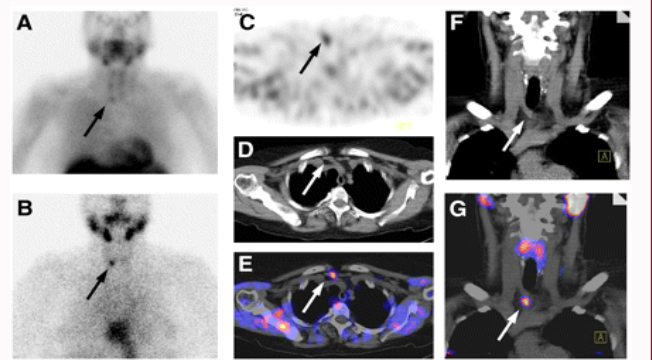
SPECT CT White Arrows (F) W/O Contrast with Contrast and G. A and B are Planar views (at 15 min B and 60 min A) of 99m TC-MIBI scintigraphy. Planar imaging is limited by precise anatomic location and the overlapping thyroid gland. (E) Indicating parathyroid adenoma below right thyroid gland (arrows). (F and G) Demonstration of parathyroid adenoma (arrows) in corresponding coronal CT (F) and SPECT/CT (G) [4].
